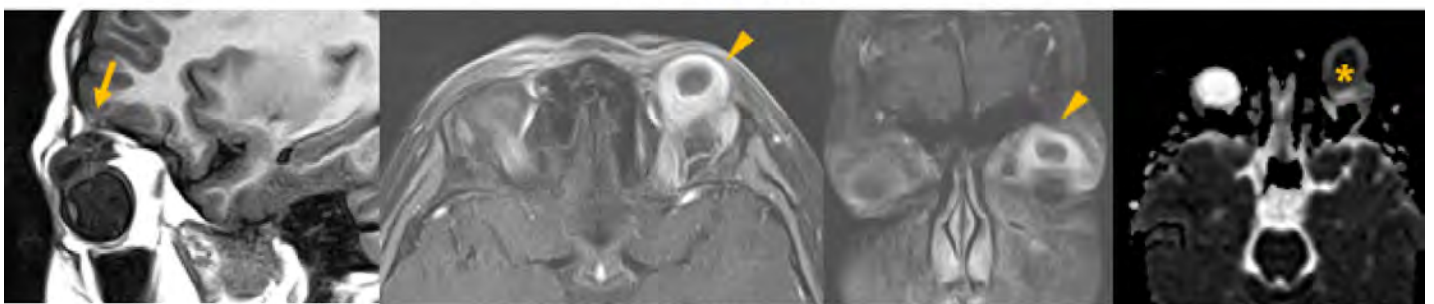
Onchocerca lupi* (nematode) abscess of the left orbit in a 10-year-old. Sagittal T2, axial and coronal STIR and axial DWI.
